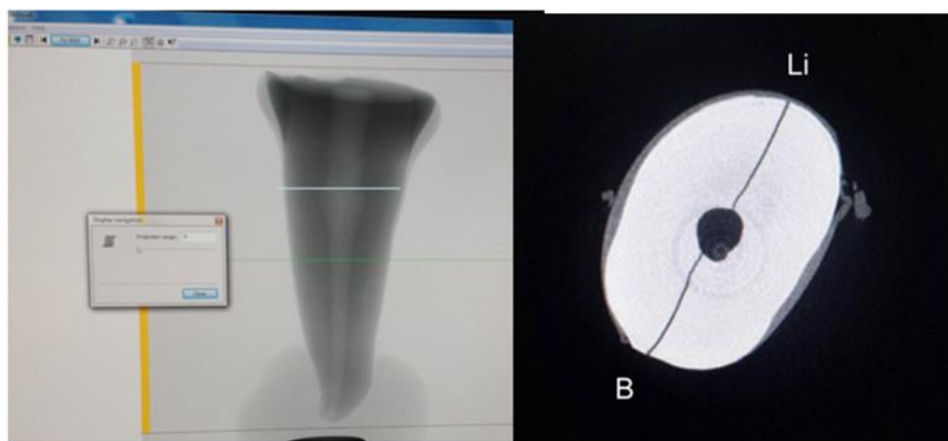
Incomplete fracture line verified with μ CT unit
